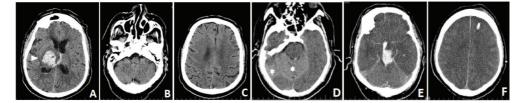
Brain Computed Tomography Images of Hypoxic-Ischemic Brain
